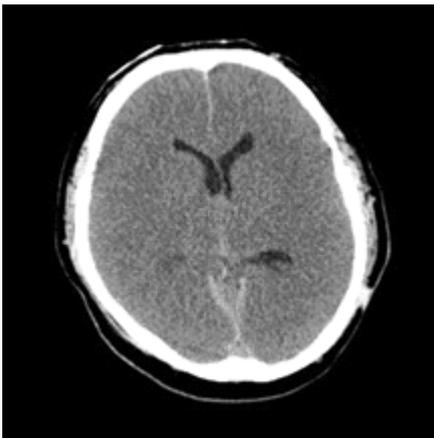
On the first day after surgery, brain CT revealed severe cerebral edema and cerebral infarction. At this time, the patient showed bilateral pupil dilatation and fixation without recovery of consciousness.
